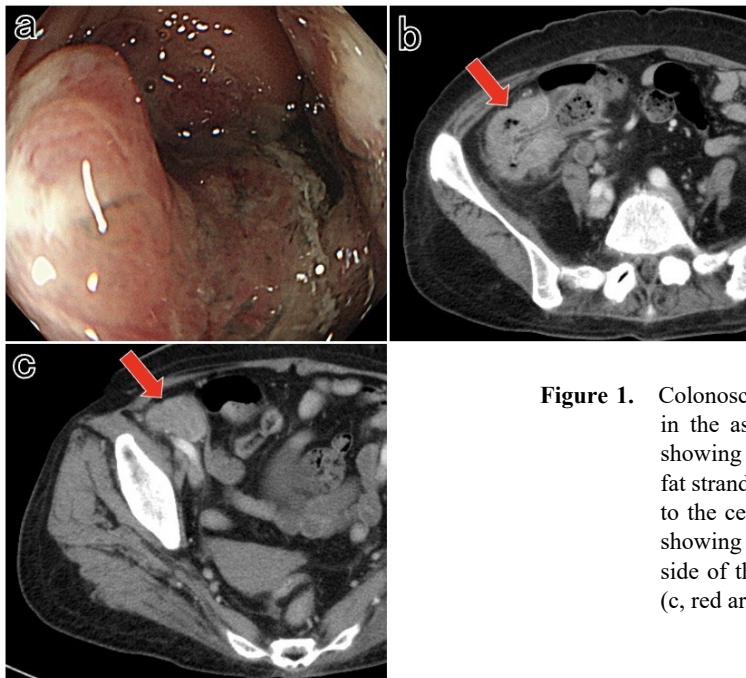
Colonoscopy revealed a type 2 tumor in the ascending colon (a). CT scan showing wall thickening and pericolic fat stranding from the ascending colon to the cecum (b, red arrow). CT scan showing a 4.5 cm mass on the anterior side of the right external iliac vessels (c, red arrow).
